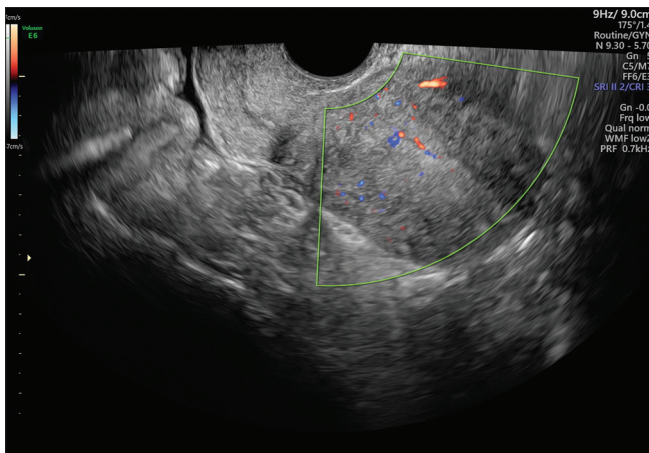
Transvaginal ultrasound image 1 month after embolization
